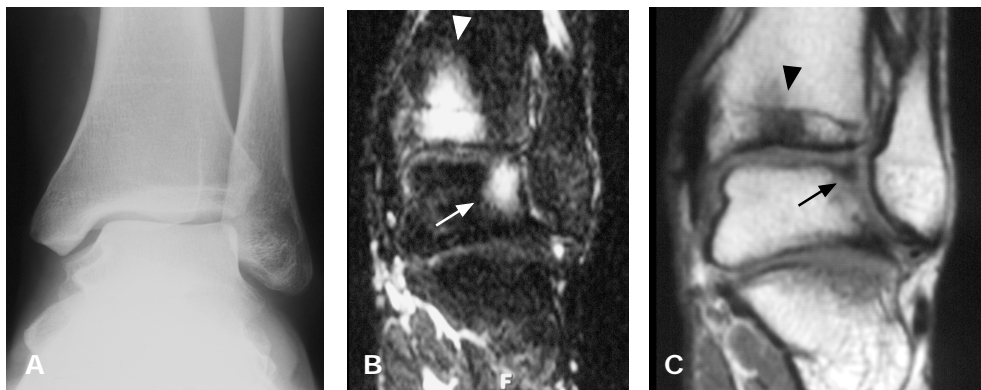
25-year-old male 7 weeks after severe sprain of left ankle. A, Anteroposterior radiograph of left ankle shows no abnormalities. B, Coronal short tau inversion recovery (STIR, TR/TE/TI 3600/20/150) shows bone contusions in opposing areas of medial tibia plafond (arrowhead) and lateral talar dome (arrow). Contusions are recognized by demonstration of areas of increased signal intensity. C, Coronal T1-weighted spin-echo (TR/TE 600/23) MR image shows osteochondral contusions in lateral talar dome (arrow) and tibia plafond (arrowhead). Contusions are not diametrically opposed probably as result of rotation.
